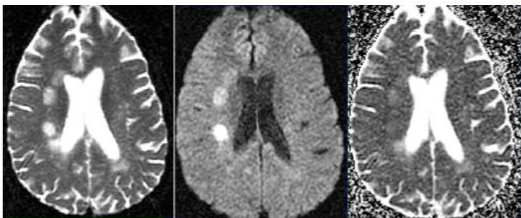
T2 shine through. Left image is a T_2 image, middle image is a DWI, and right is an ADC[4].
